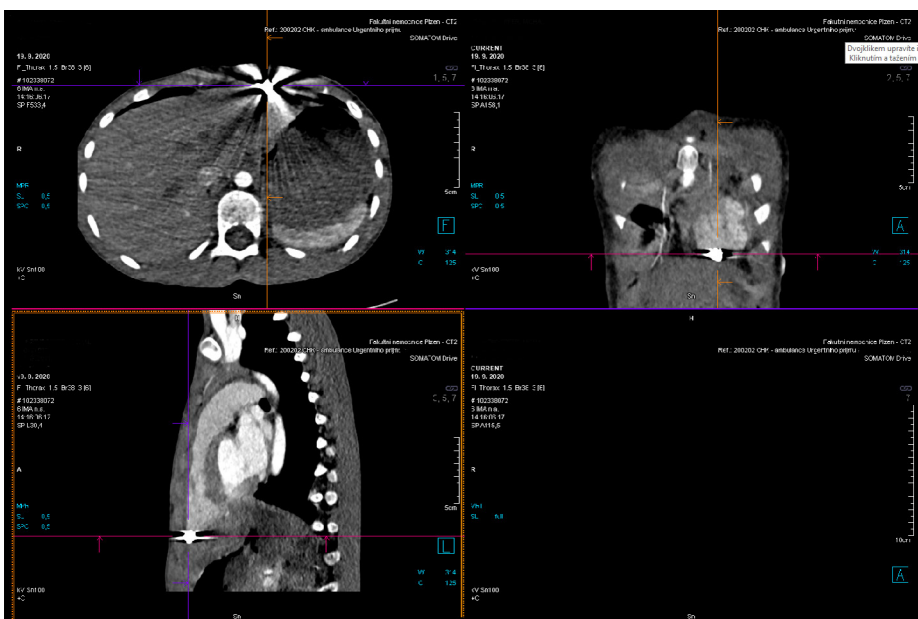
Computed tomography images of the projectile in the left portion of the chest.
